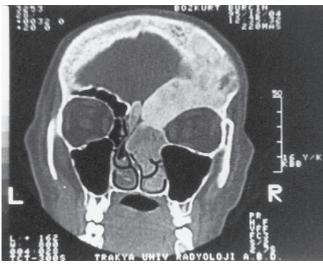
Coronal CT scan revealing FD of the right ethmoid and frontal sinuses, right middle turbinate, and right frontal and parietal bones.
